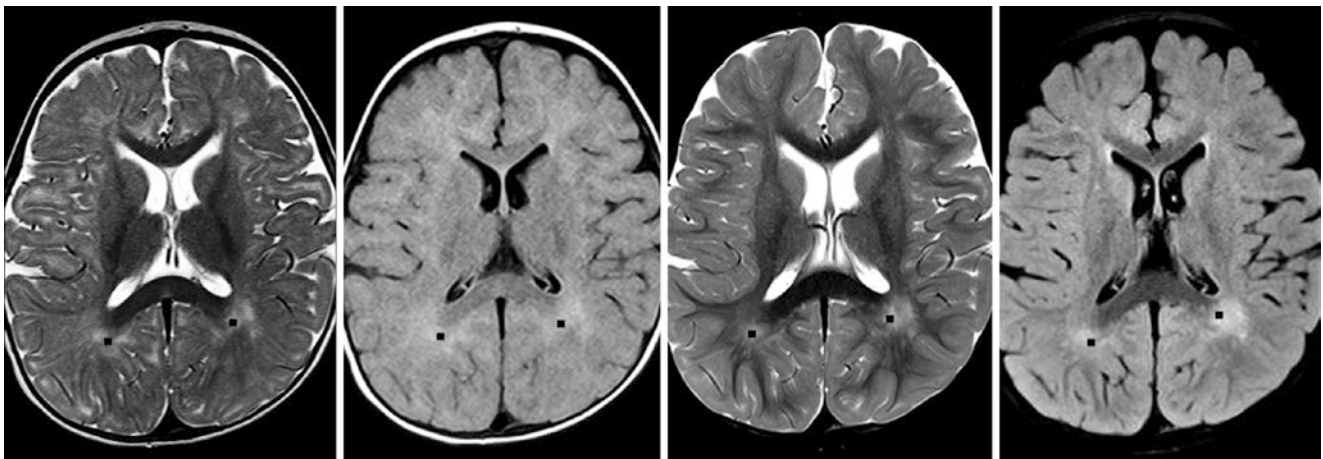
Comparison case of 3-methylglutaconic aciduria (type I). An 11-month-old with microcephaly (by history) had multifocal, abnormal deep WM and PVWM (*squares*) on a 3T MRI with SE T2WI (*left*) and FLAIR (*left middle*), while the CG, CS, ALIC, and SCWM
